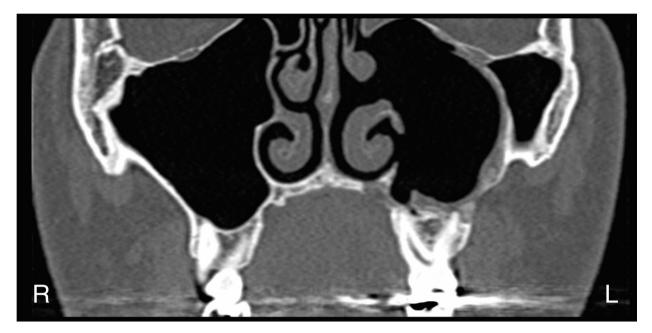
CT coronal view 6 months after surgery, showing inferior and middle meatotomies, normal sinus mucosa thickness, no sinus radiopacity, integrity of tooth 26, and remains of the bony walls that surrounded the follicular cyst.
